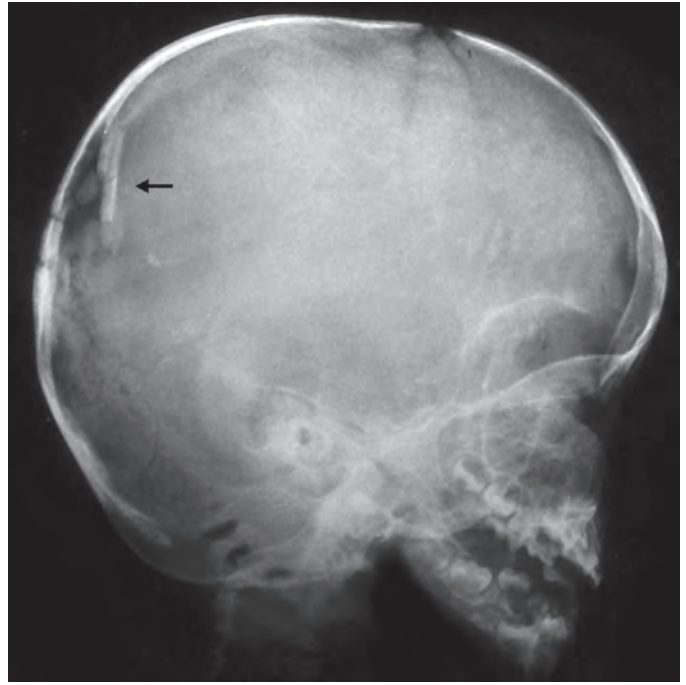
Depressed fracture X-ray
